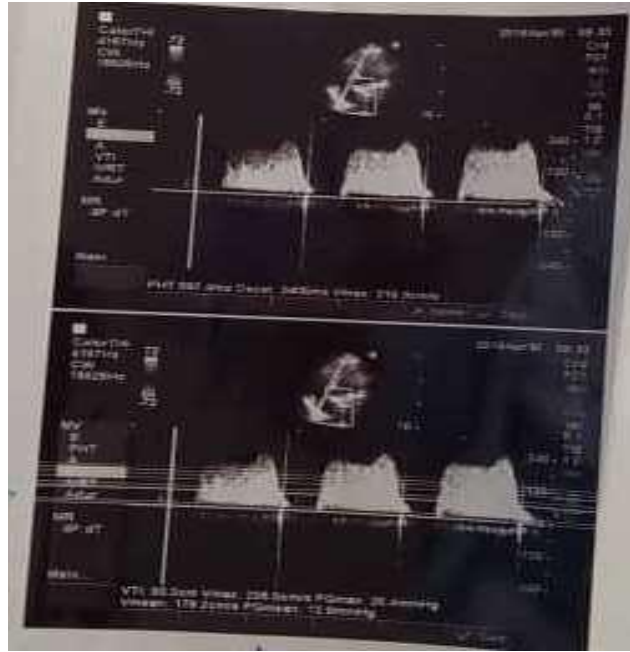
Transthoracic echocardiography before third surgery
